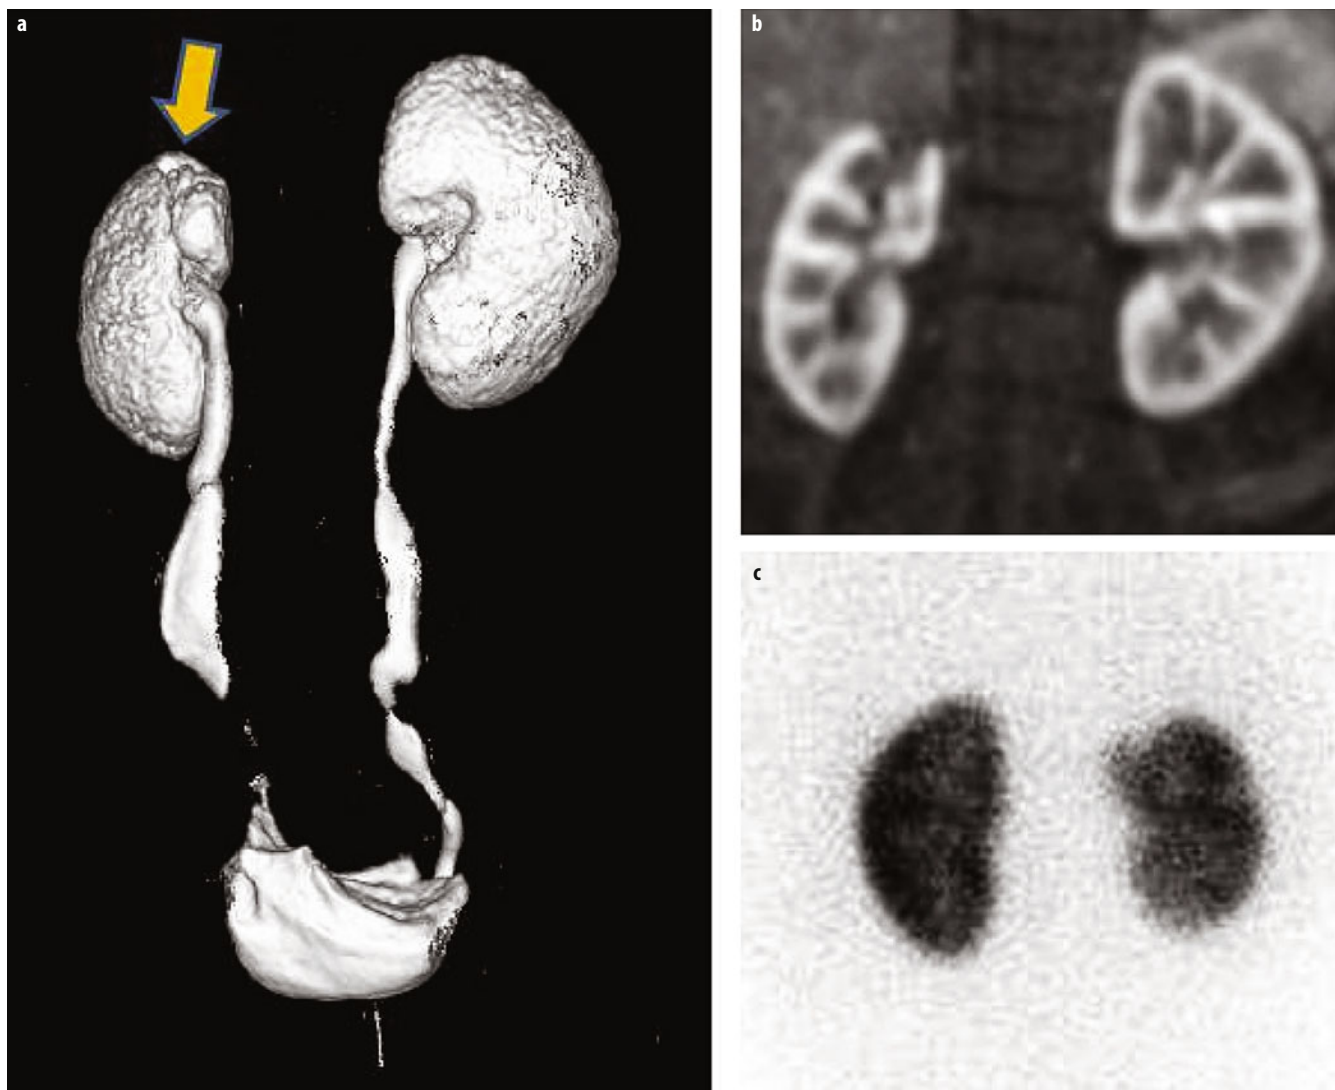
a-c. Cortical renal scarring. The right kidney has a scar in the upper part of the kidney which is clearly seen on the maximum intensity projection (MIP) derived from the delayed, T1-weighted volume (*arrow*) (a) and on the arterial phase MR images (b). For comparison a nuclear medicine dimercaptosuccinate (DMSA) study is shown (c); this image follows the nuclear medicine convention which corresponds to a posterior view and hence the scarred kidney is now on the reader's right
